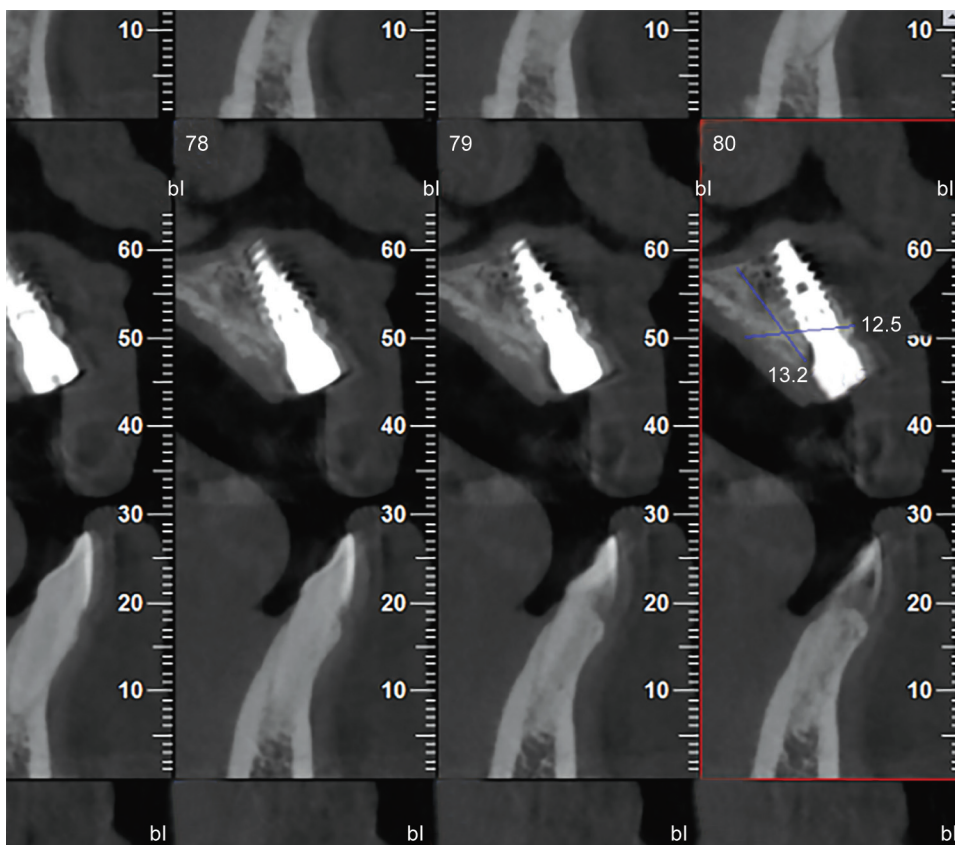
Sagittal CBCT at the time of implant exposure
